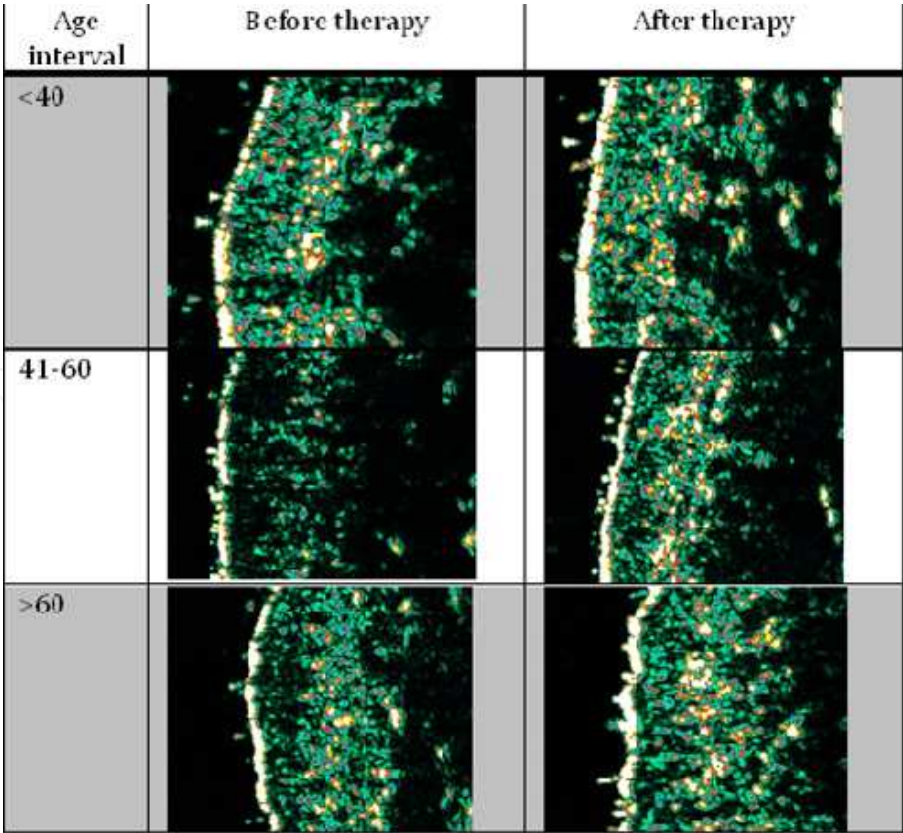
Ultrasonographic skin aspect before and after topical therapy, on different age intervals
